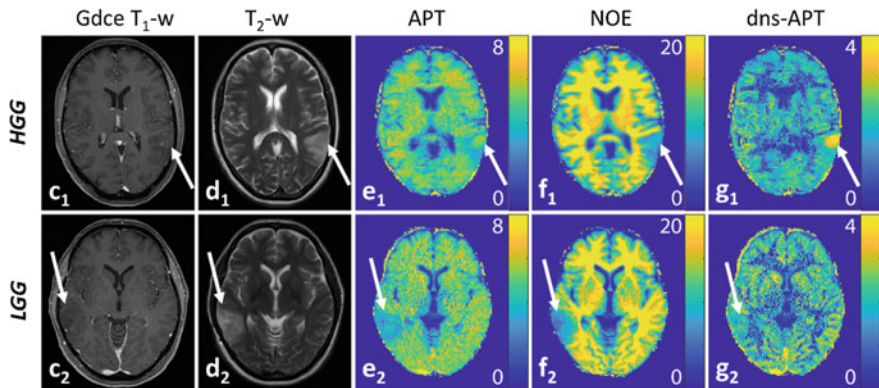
Association CEST MRI and WHO tumor grade (HGG vs. LGG) in newly diagnosed untreated glioma patients. Two exemplary patients with high-grade glioma (HGG: glioblastoma, c_1 – g_1) and low-grade glioma (LGG: Oligodendroglioma II, c_2 – g_2) shown: c_i : Gdce T1-w, d_i : T2-w (TSE), relaxation-compensated multi-pool CEST MRI at 7T with separated APT (e_i), NOE (f_i), and downfield NOE-suppressed (dns)-APT (g_i) effects [unit: %]. Increased APT signals can be observed in the HGG tumor, especially at dns-APT imaging whereas the LGG tumor displays hypo-/isointense to surrounding normal appearing tissue. The glioblastoma patient shows only a small spot-like contrast enhancement in the tumor region (c_1) while a clear hyperintensity displays within the tumor at dns-APT imaging (g_1 , white arrow). © *Neuro-Oncology*, Oxford Academic, Paech et al. Volume 20, Issue 12, 12 November 2018, pp. 1661–1671
